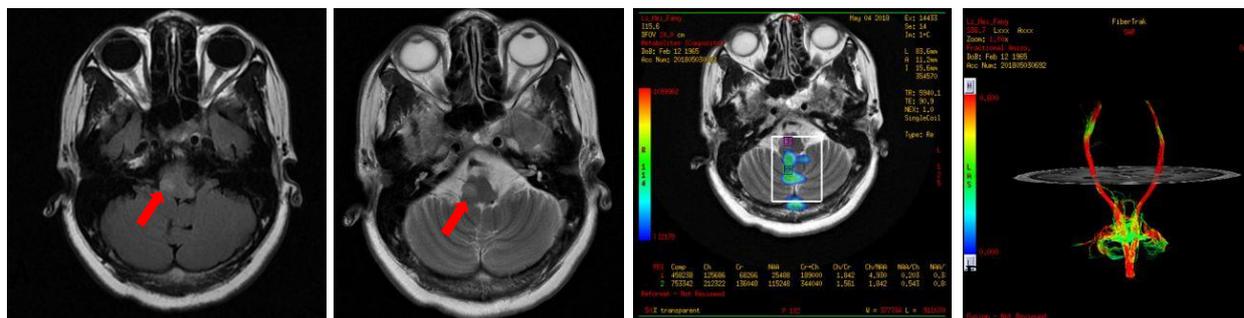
(A) MRI T1W1 Scan showed low signal (red arrowed), (B) T2W2 Scan showed slightly high signal (red arrowed), (C) MRS showed a decreased NAA peak, Cr peak, CH peak, NAA/ CH peak, and CH/Cr peak, (D) DTI showed that no obvious fiber destruction was observed.
